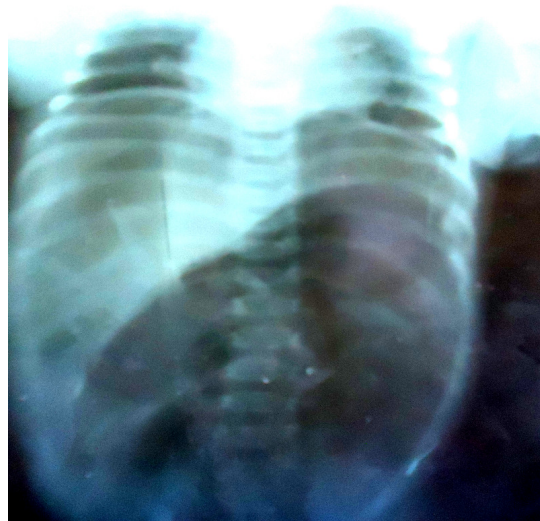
Plain Abdominal X-ray of the Neonate with Pneumoperitoneum
